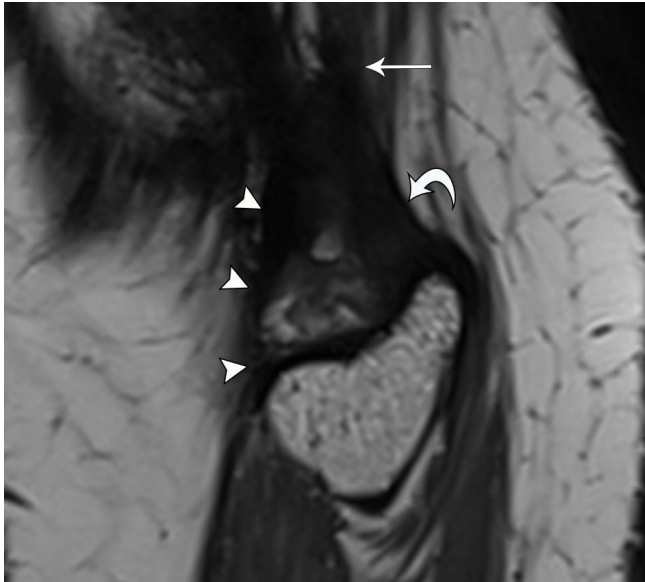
33-year-old female with snapping sensation at the lateral knee. Dynamic US imaging (see Video 1) shows snapping of the tibial arm of the biceps femoris tendon. Note initial orientation of the probe in the longitudinal plane before turning to short axis before imaging about the fibular head. Sagittal PD SPACE MR image shows thickened tibial arm (arrowheads) bifurcating from the biceps femoris tendon (arrow) and coursing anterior to the fibular arm (curved arrow)
